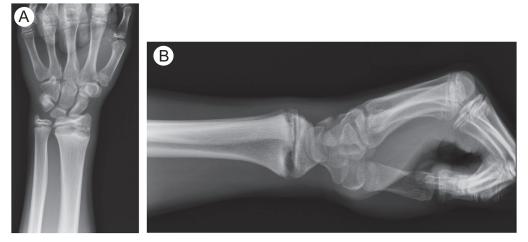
A 13-year-old female gymnast with increasing left wrist pain preventing competition. (A) Anteroposterior x-ray with widening and irregularity of the physis. (B) Lateral x-ray with widening more on the volar aspect. (*Courtesy:* Shriners Hospitals for Children, PA)
